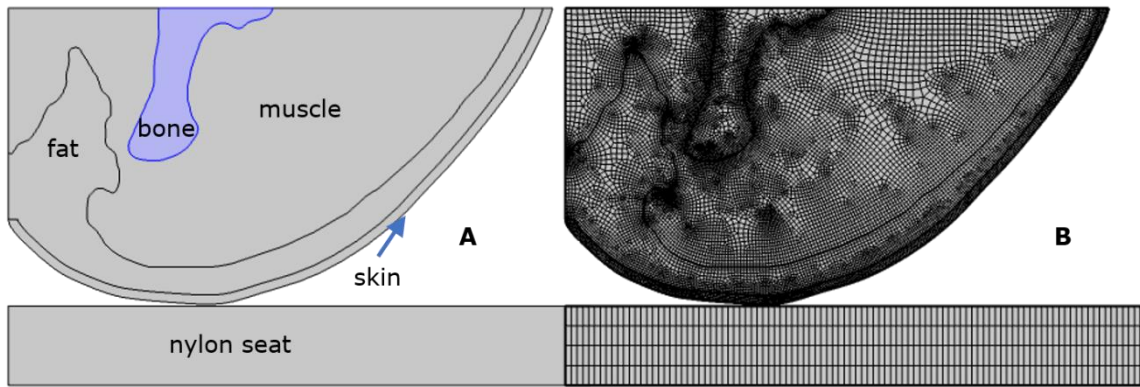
Plate A shows the four tissue regions as segmented manually from the MRI image for the non-SI subject. Plate B shows the quadrilateral meshed tissue domains. Total mesh elements are 16956
